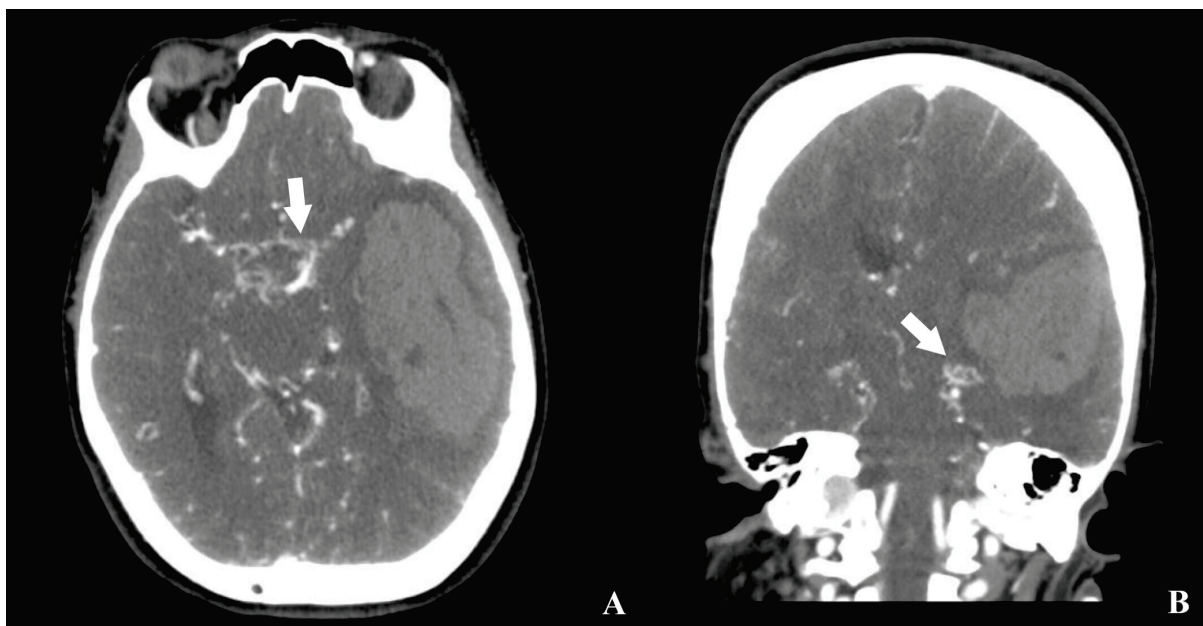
Preoperative brain CTA of the patient ((A) axial, (B) coronal, white arrow: revascularized region adjacent to the hemorrhage).
